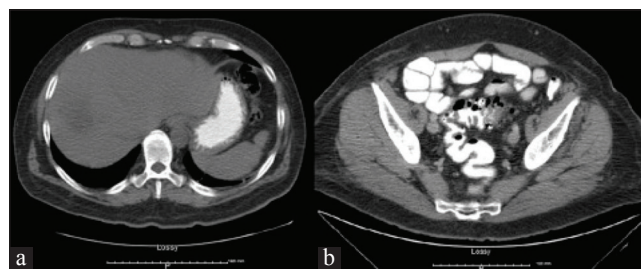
(a left) Abdominal CT scan showed ill-defined lobulated hypodensity in the dome of the right lobe of liver measuring 4.5 cm × 3.4 cm × 5.5 cm consistent with liver abscess (b right) CT scan showed marked thickening of the proximal sigmoid colon with diverticula compatible with diverticulitis. That may be the source of the patient's liver abscess
